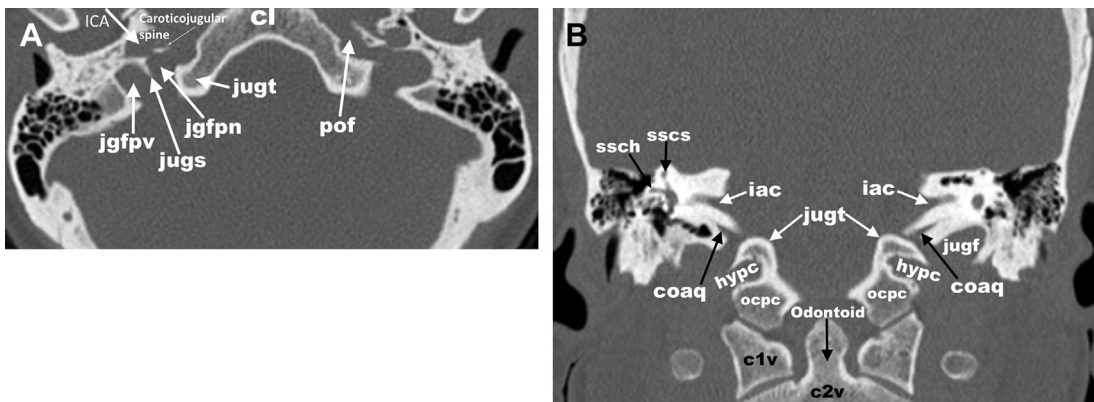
Normal CT anatomy of the jugular region. Axial CT (A) and coronal CT (B) demonstrate normal bony anatomy and relationships. cl, clivus; c1v, C1 vertebra; c2v, C2 vertebra; coaq, cochlear aqueduct; hypc, hypoglossal canal; iac, internal auditory canal; ICA, vertical segment of petrous ICA; jgfpn, pars nervosa of jugular foramen; jgfpv, pars vascularis of jugular foramen; jugf, jugular foramen; jugs, jugular spine; jugt, jugular tubercle; ocp, occipital condyle; ssch, horizontal semicircular canal; sscs, superior semicircular canal. (Courtesy of Neil Borden, MD, Pittsburgh, PA.)
